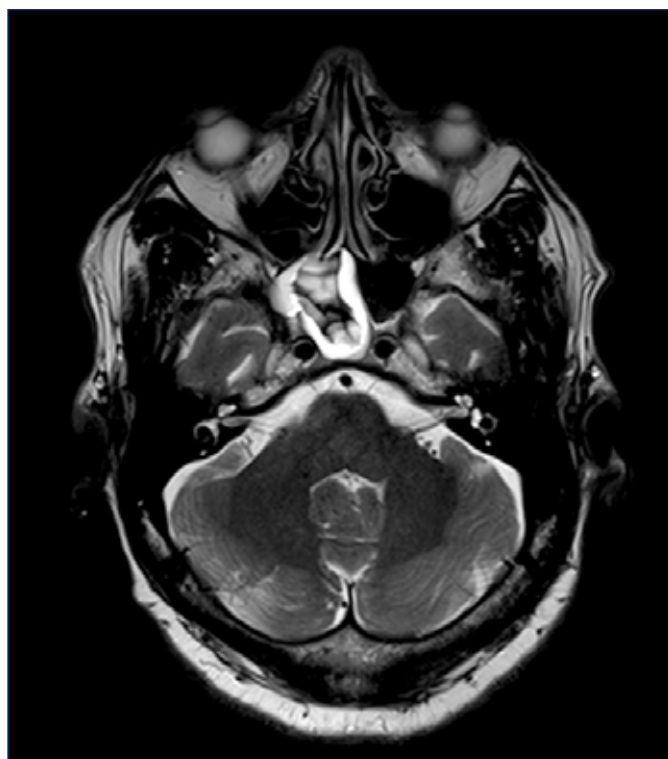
Transverse T2-weighted gadolinium-enhanced MRI.Table 1. Pan-hormone studies relative to post-GnRHa injection date.
